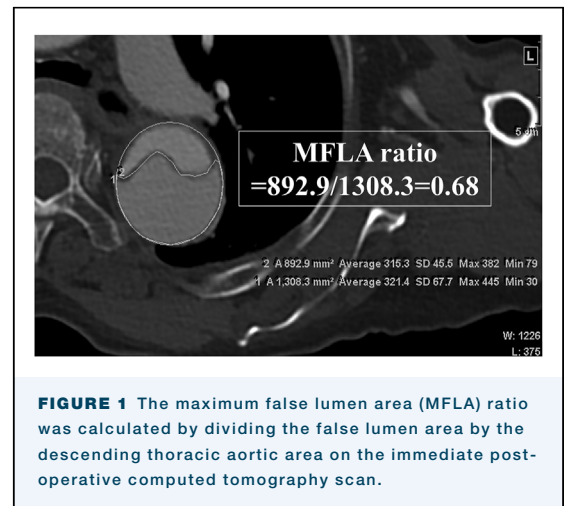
The maximum false lumen area (MFLA) ratio was calculated by dividing the false lumen area by the descending thoracic aortic area on the immediate postoperative computed tomography scan.
